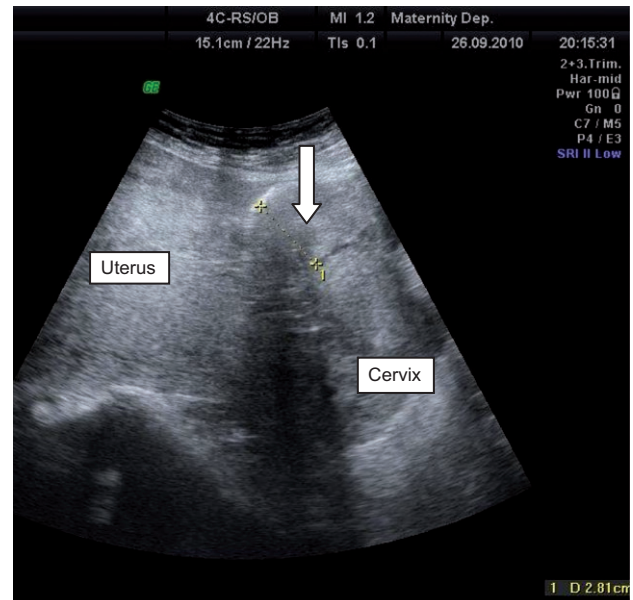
Two-dimensional ultrasound of the uterus demonstrating an irregular hyperechoic area (arrow) at the lower uterine segment, representing possible blood clot covered with the peritoneum. In this case, active bleeding was through the vagina.
